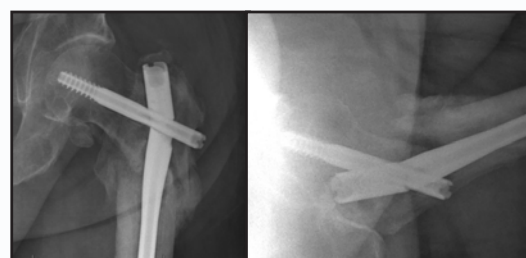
Radiographs demonstrating hardware failure and nonunion at the fracture site.
